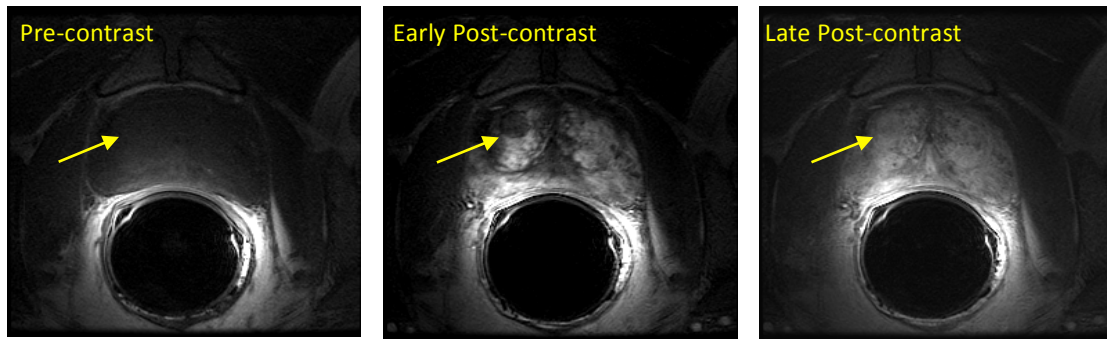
DCE-3D MRI of prostate. Note the features of the BPH nodule (yellow arrows), the visualization of the prostate capsule and of structures of the neurovascular bundle, as well as the superb anatomical information intraglandular. Bloch et al., Acad Radiol 2004; 11:863-867
